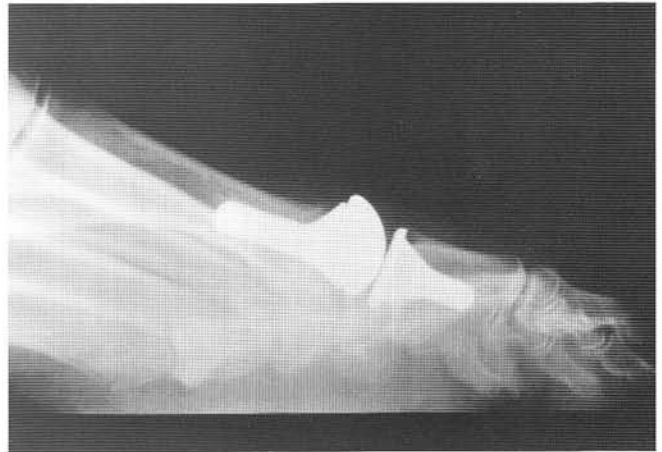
Laterally x-ray demonstrating the dorsally set position of the implant resulting in restriction of motion.
